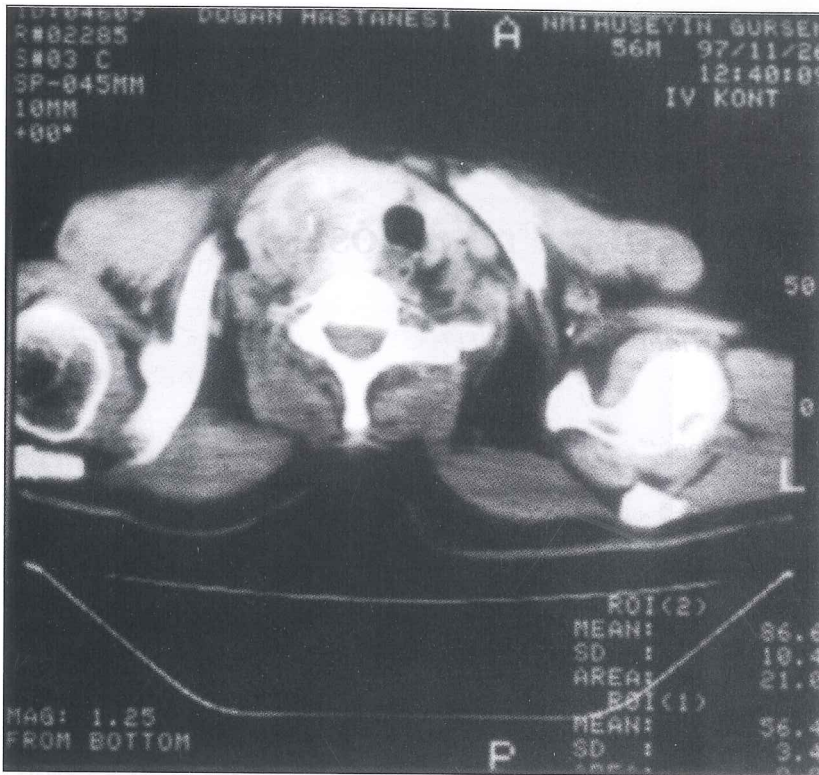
Chest CT on the right upper paratracheal area huge intrathoracic thyroid nodules.
